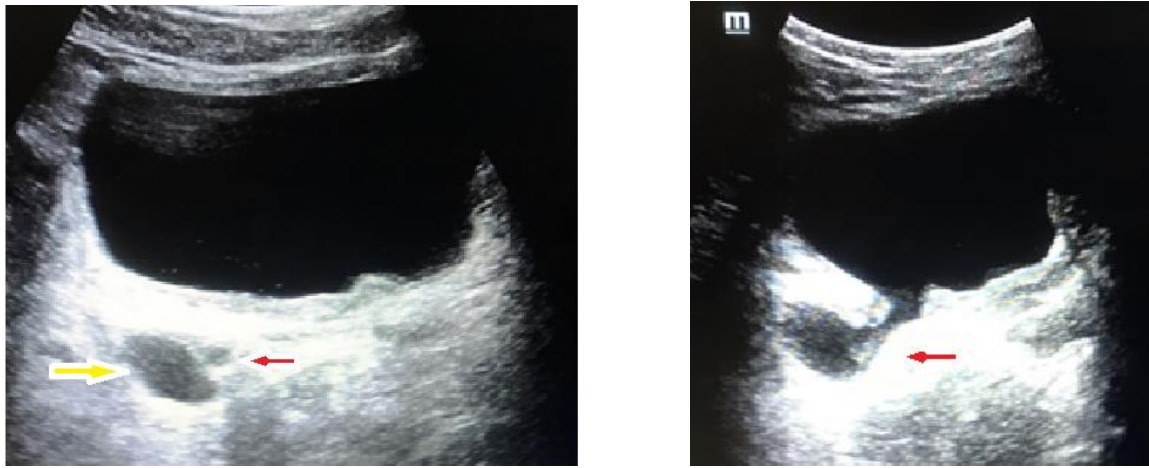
Ultrasound pelvis showing bladder diverticulum (yellow arrow) arising in the vicinity of right vesicoureteric junction (VUJ). Mild dilatation of right distal ureter (red arrow) is seen in its medial relation.
